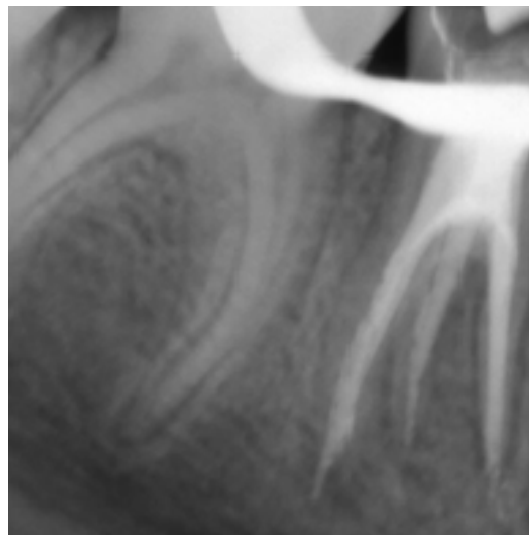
Periapical radiograph of the tooth with filled root canals.
